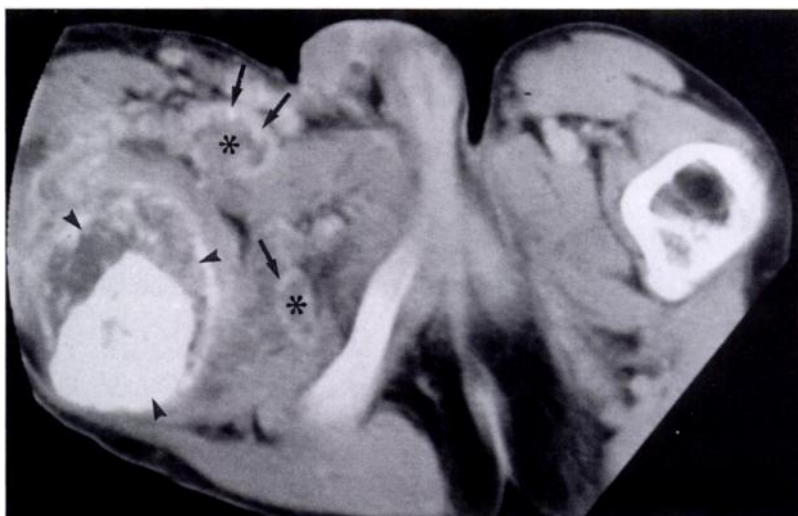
Regional lymph node metastases in a 17-year-old boy with high-grade intramedullary osteosarcoma of the proximal femur. Axial CT scan shows both intra- and extraosseous components (arrowheads) of a femoral lesion. Inguinal and obturator lymph node metastases (*) are also seen with small foci of mineralization (arrows).
